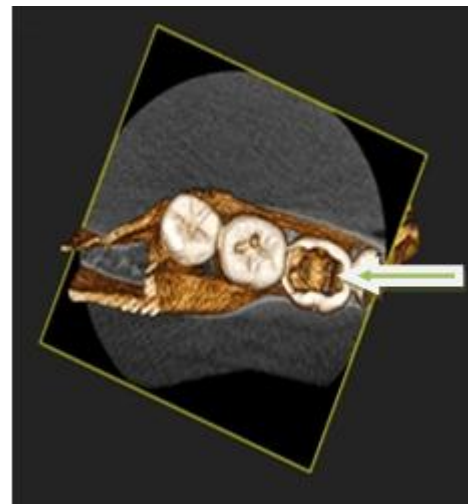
Three dimensional occlusal view – PRE CBCT – detecting three separate orifice at mesial side.
